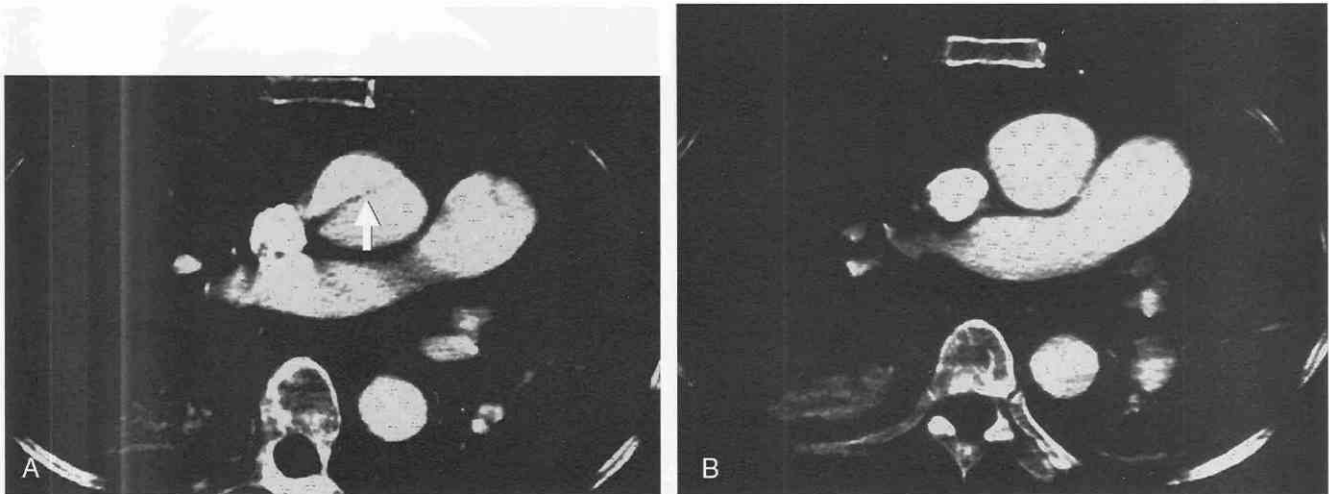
A, Axial CT scan above the aortic valve shows an apparent linear density mimicking dissection in the ascending aorta, secondary to a beam-hardening artifact from the presence of contrast agent in the superior vena cava (arrow). B, Axial CT scan superior to scan in A shows a normal ascending aorta with no evidence of dissection.
